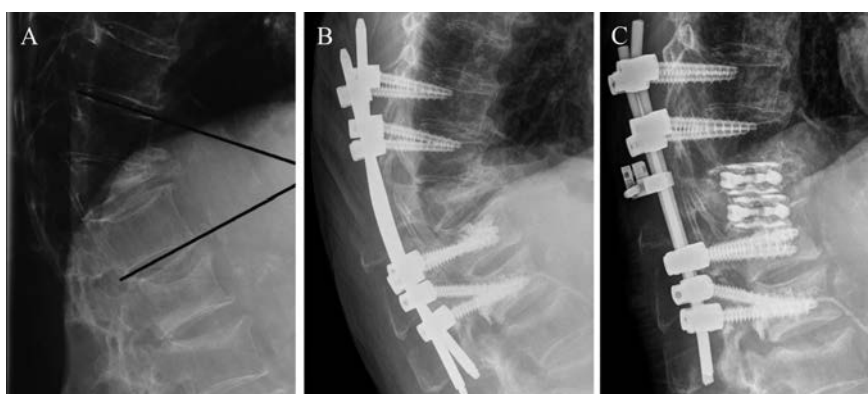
Radiographic follow-up: the lateral view of collapsed T12 with hyperkyphosis and the thoracolumbar junction (A), reposition of the hyperkyphosis failed. Cemented screws were applied (B), postoperative x-rays of the double transforaminal lumbar interbody fusion osteotomy 12 days after surgery (C).
